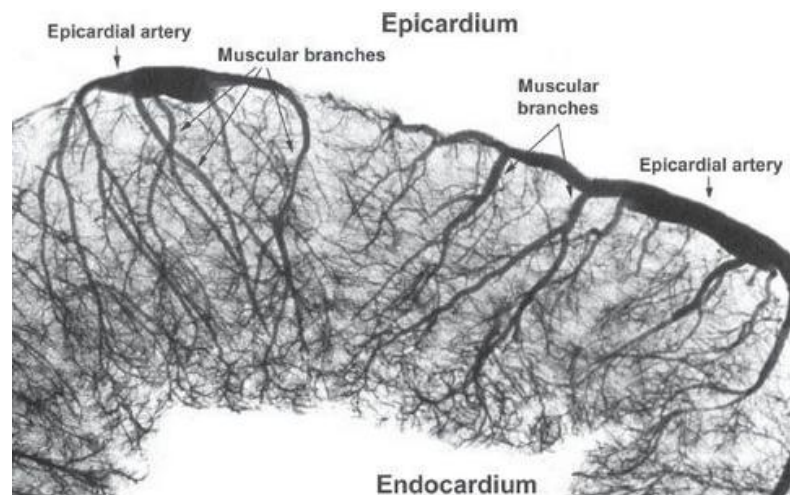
X-ray microphotograph of transversal section of the left ventricle after injection with radiopaque dye (Katz AM, 2010)
